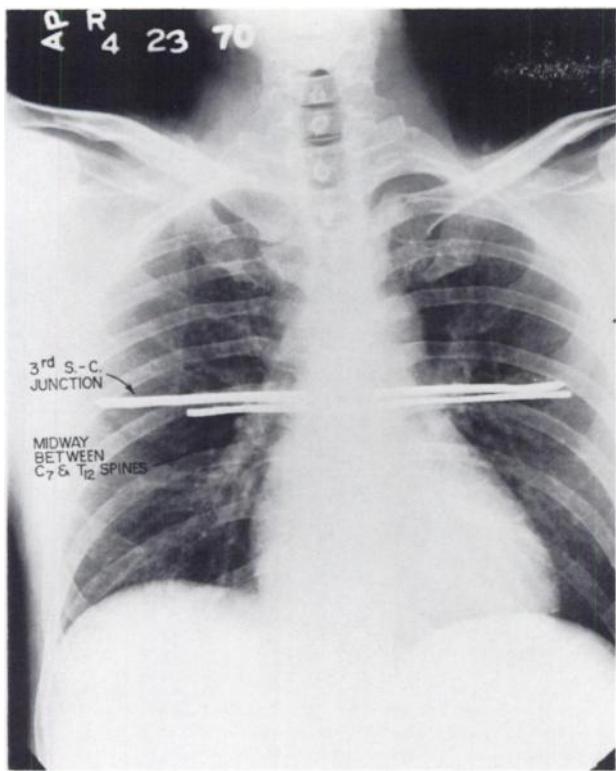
Six-foot chest x-ray demonstrating identical plane of division of lungs in both anterior and posterior views. Thin lead ribbon is placed, one overlying transverse line at third sternocostal junction anteriorly, and another overlying transverse line midway between cervical C₇ and thoracic T₁₂ spines posteriorly. X-ray tube was 6 ft away from subject. Both lines superimpose over one another indicating plane of division of lungs as upper zone (UZ) and lower zone (LZ) is same for both anterior and posterior views.
